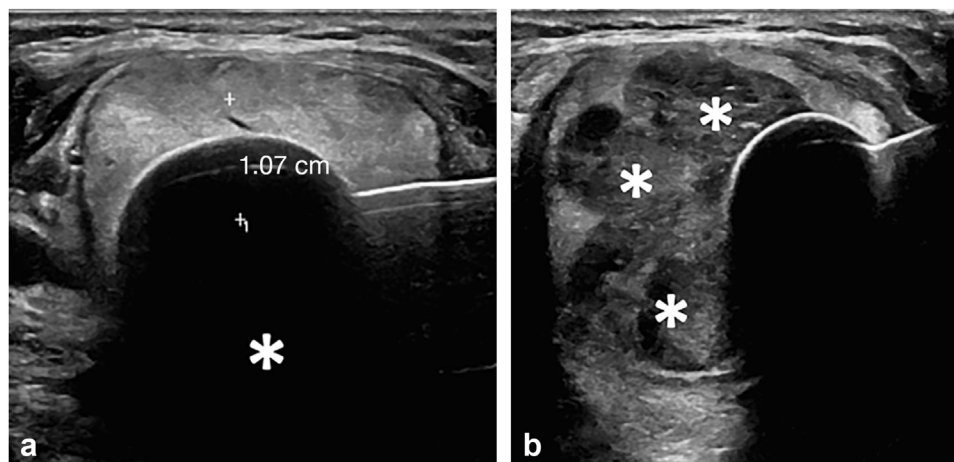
Ultrasound imaging of the thyroid nodule during cryoablation. (a) Longitudinal view of the initial ice ball formation. Measurement of the anterior radius (between calipers). Posterior acoustic shadowing from the ice ball formation (asterisk). (b) Final immediate hypoechoic areas of the multiple overlapping sessions (asterisks) of thyroid nodule cryoablation under ultrasound guidance.
